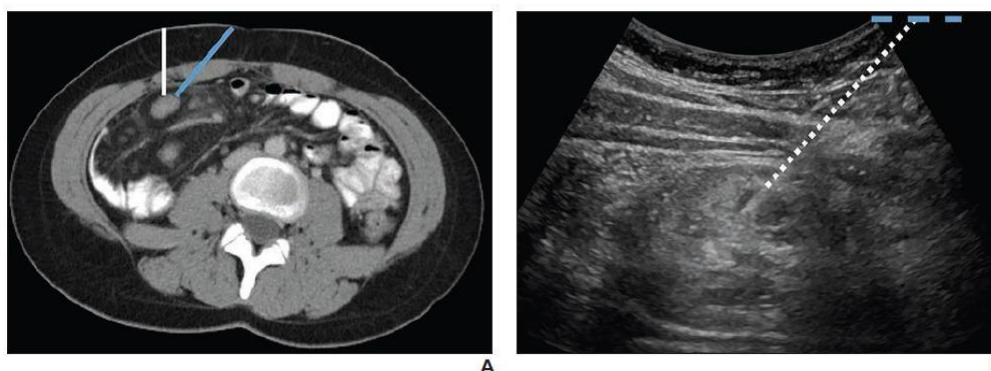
The white line shows that the shortest distance from the skin to the perpendicular node is about 4.4 cm. A oblique method (blue line) could have been used with CT to get a longer surgical core and avoid hitting the bowel and mesenteric blood vessels directly. About 6 centimetres separate the two points. An ultrasound picture taken during a biopsy with the tissue compressed and the needle in place shows a more angled approach (dotted line). Even though compression has been used, the gap is still about 6 cm. The dashed line shows where the skin is thought to be.
